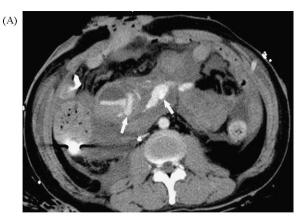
A 51-year man after gastric surgery presented with unstable vital signs and symptoms of AGIB. The initial endoscopy failed to localization of the active bleeders. (A) Arterial phase CT scan on axial plane showed large amount of contrast extravasation (white arrows) into the 3rd and 4th portion of duodenum. (B) Angiography showed active bleeding of the inferior branch of gastroduodenal artery. After transarterial embolization with gelform pieces, the bleeding ceases.
